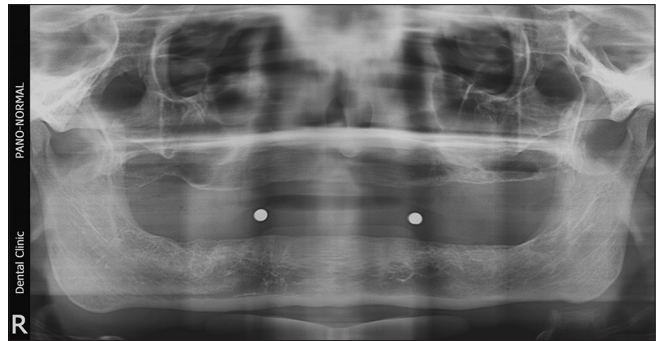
Digital pantomogram with radiographic stent
